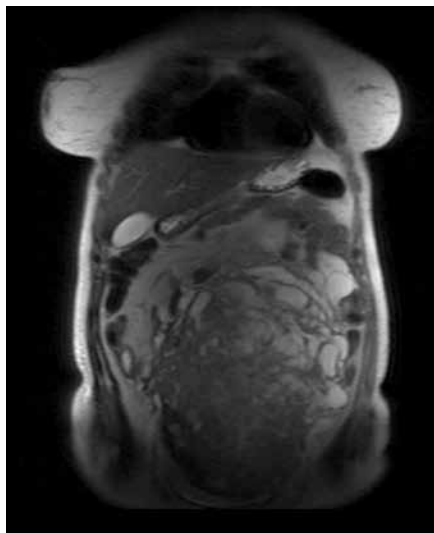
Magnetic resonance image of the patient in the sagittal section
